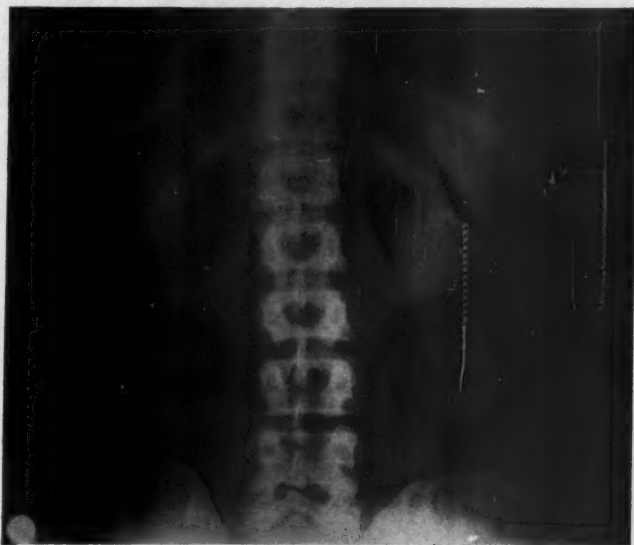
Air injection x-ray of Case 1. Showing the large rounded adrenal tumor in front of the left kidney and arising from the lower pole of the adrenal. Proved by operative removal. Recovery.
